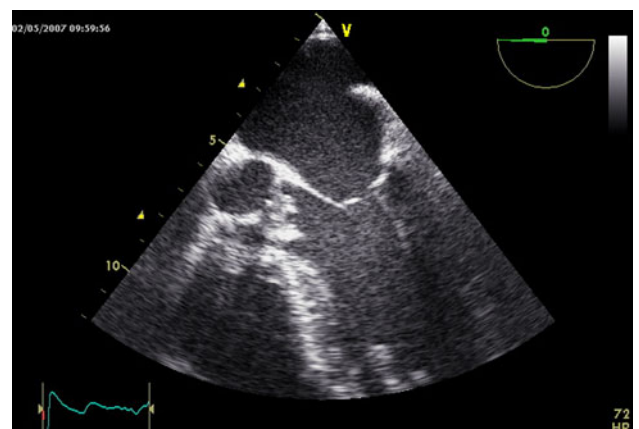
Transesophageal echocardiographic image, showing large vegetations on the aortic cusps
